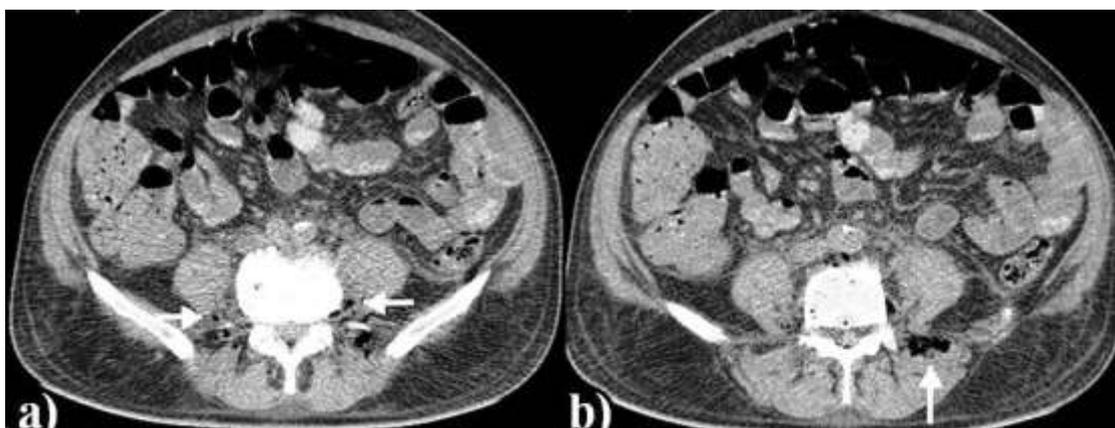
Axial Non contrast CT images of the abdomen showing presence of air loculi in the bilateral psoas, left iliacus and left erector spinae muscles (white arrows)
